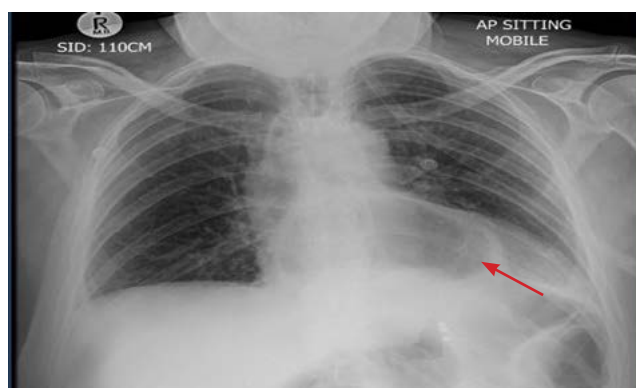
Chest radiograph demonstrating an intrathoracic air–fluid level (red arrow) consistent with intrathoracic migration of the stomach within a para-oesophageal hiatal hernia
